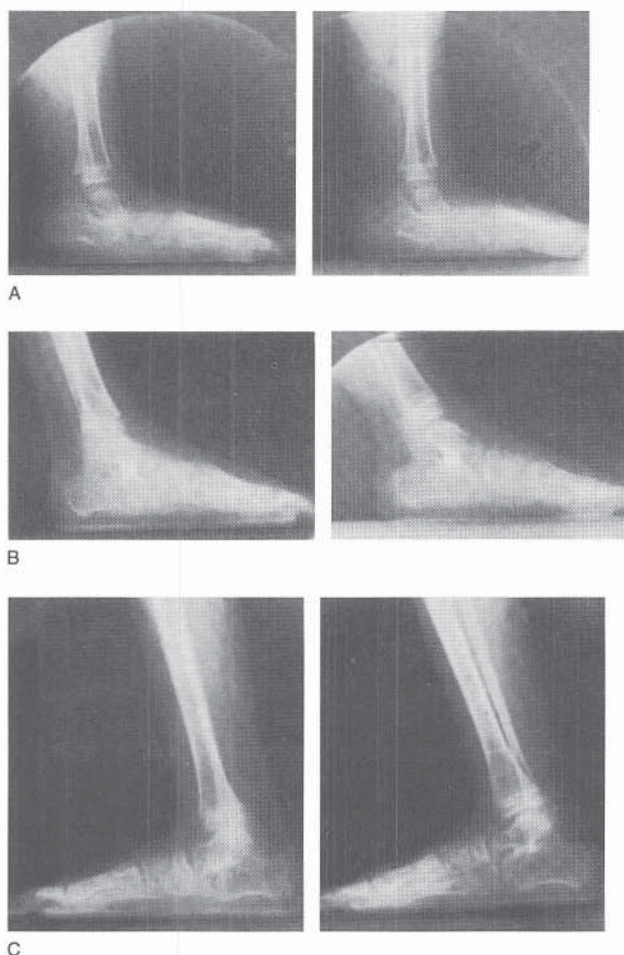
A, Weightbearing lateral radiograph of a patient with pes equinovagis. B, Radiograph obtained 8 months after Achilles tendon lengthening and Grice extra-articular arthrodesis. C, Lateral radiograph obtained 3 years 6 months postoperatively.
